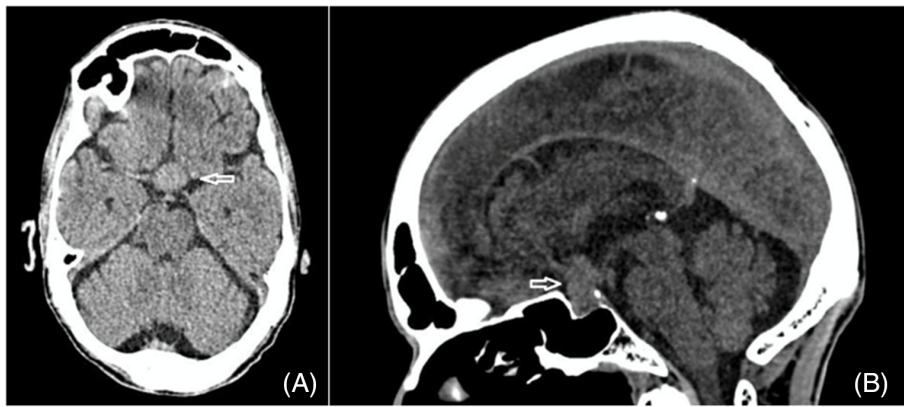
CT scan of the brain (A) axial view (B) sagittal view showing an isodense intrasellar mass with suprasellar extension
